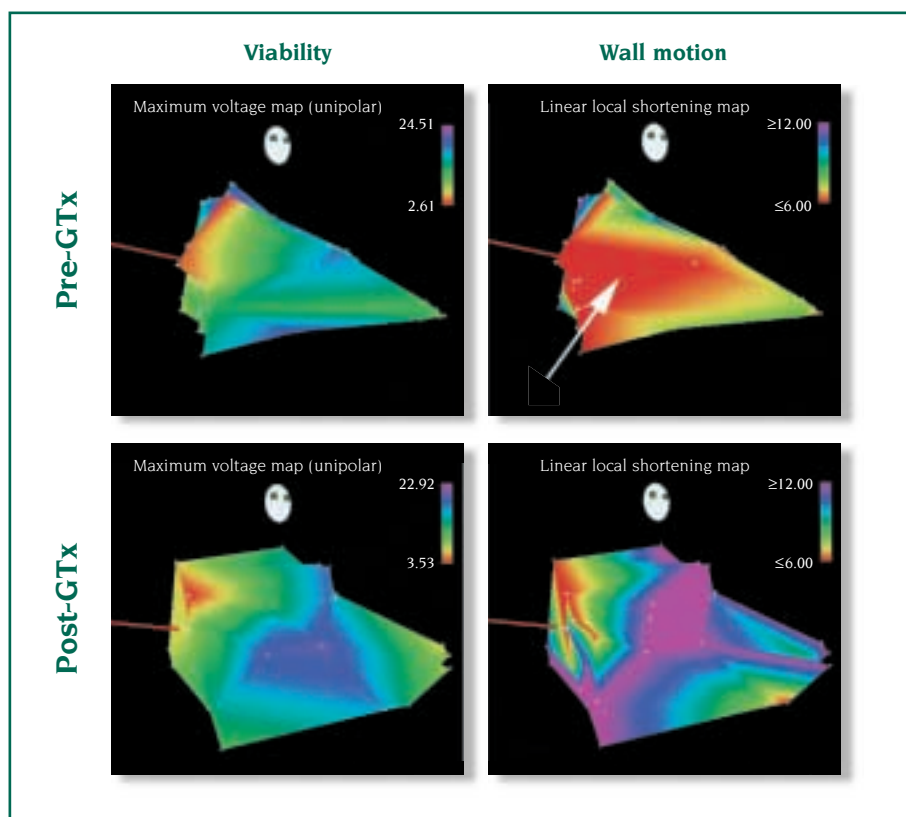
NOGA™ left ventricular (LV) electromechanical mapping (EMM) performed in a 48-year-old male. NOGA™ images in the right anterior oblique (RAO) projection prior to gene transfer (GTx) show the unipolar voltage (UpV) map (upper left panel) with normal voltages suggestive of viable myocardium (purple/pink/blue/green) and the linear local shortening (LLS) map (upper right panel) with a large zone of abnormal wall motion (red, arrow) representing electromechanical uncoupling that suggests ischemic or hibernating myocardium predominantly involving the septum. UpV and LLS maps in the RAO projection 60 days following GTx (lower left and right panels, respectively) demonstrate almost complete resolution of the ischemic zone (ischemic area 9.57 cm² pre-GTx vs 0.39 cm² post-GTx). Changes in LLS correspond with changes observed on single photon emission computed tomography (SPECT) scan (Figure 6). Red line represents long axis through the apex.
